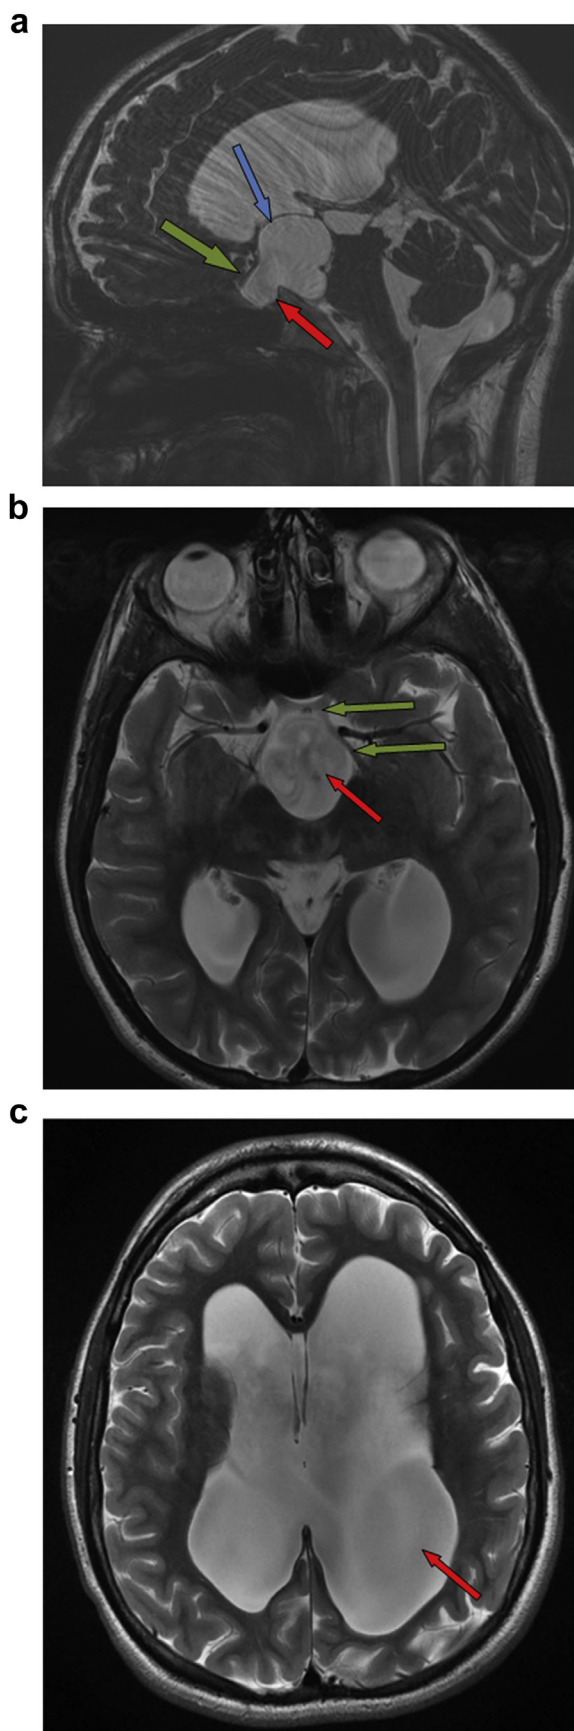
(A): 3D Fiesta T2-weighted sagittal MRI of brain: Large sellar and suprasellar lobulated expansive cyst
